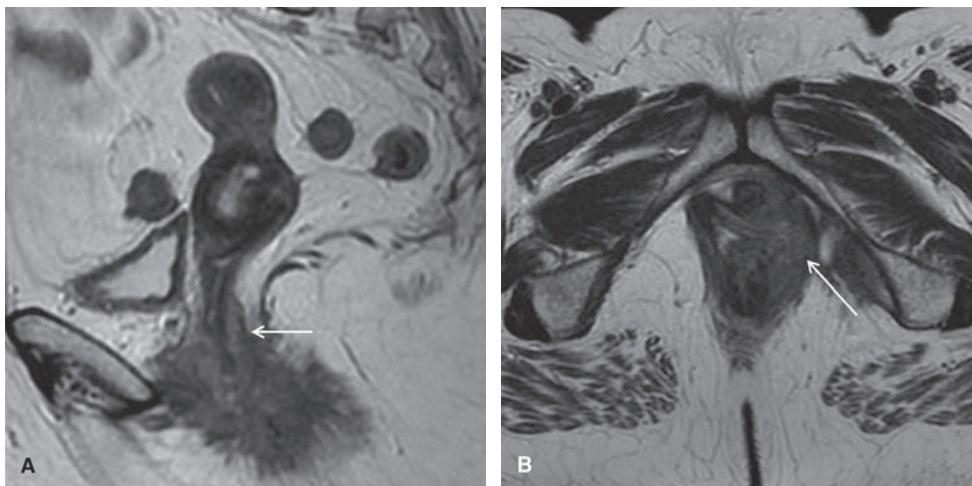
Vaginal carcinoma. Sagittal (A) and axial T2W FSE MR images demonstrate soft tissue thickening of the posterior vaginal wall (arrow in A, B).
